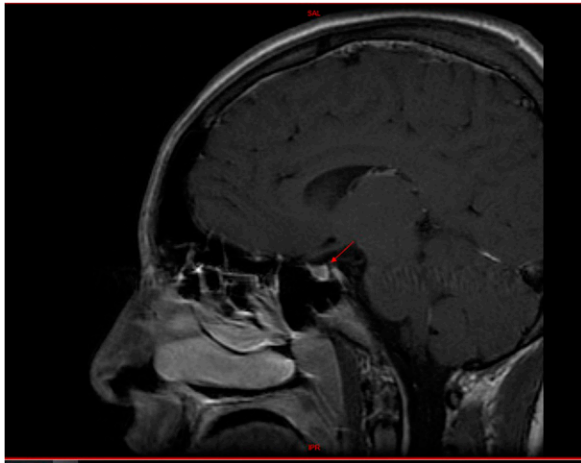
Magnetic resonance image showing pituitary adenoma.
